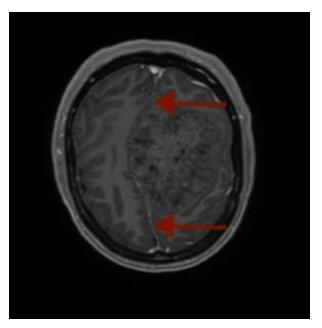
Axial DWI. Extra axial, smoothly contoured, mass located parasagittal to the left of the falx cerebri. No signal is visible in tumor.
